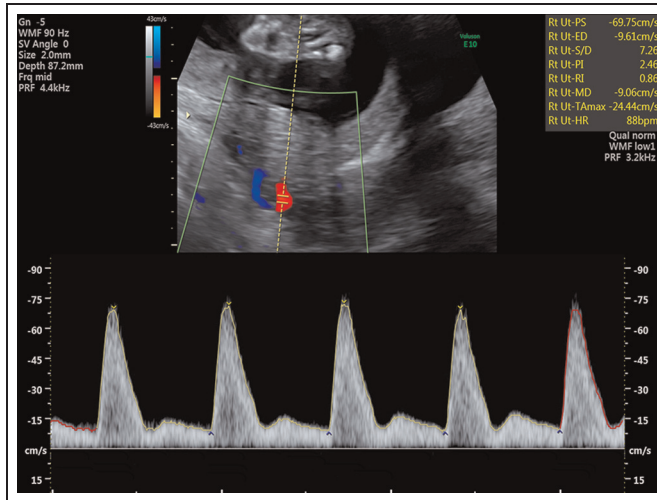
Sonographic images of the uterine artery Doppler waveform with notching.
